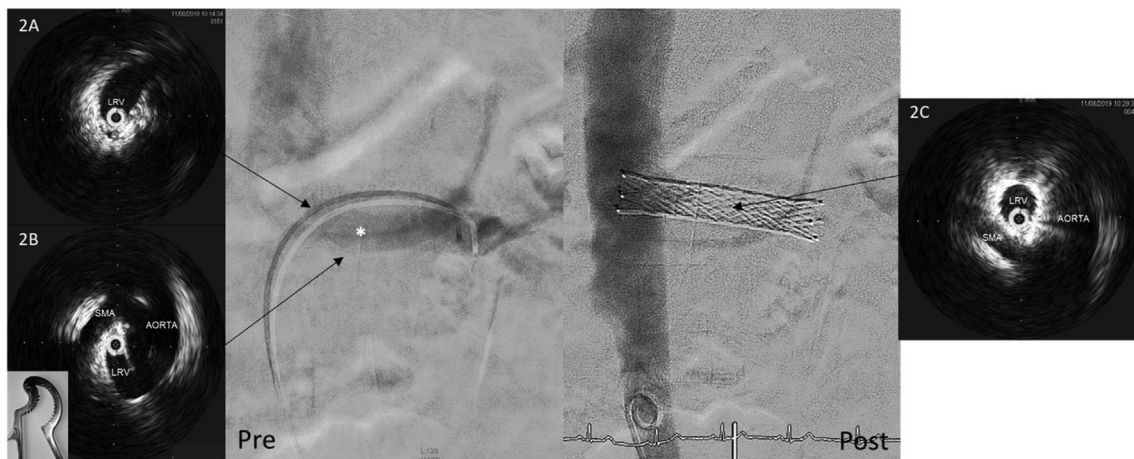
Venography of pre- and post-venous stenting of left RV. IVUS image 2A shows proximal left RV as reference, 2B shows compression of left RV between the aorta and the SMA, with a picture of nutcracker as a reference to its namesake, and 2C shows good expansion of left RV after stenting against the compression. IVUS: intravenous ultrasound, SMA: superior mesenteric artery, RV: renal vein.
